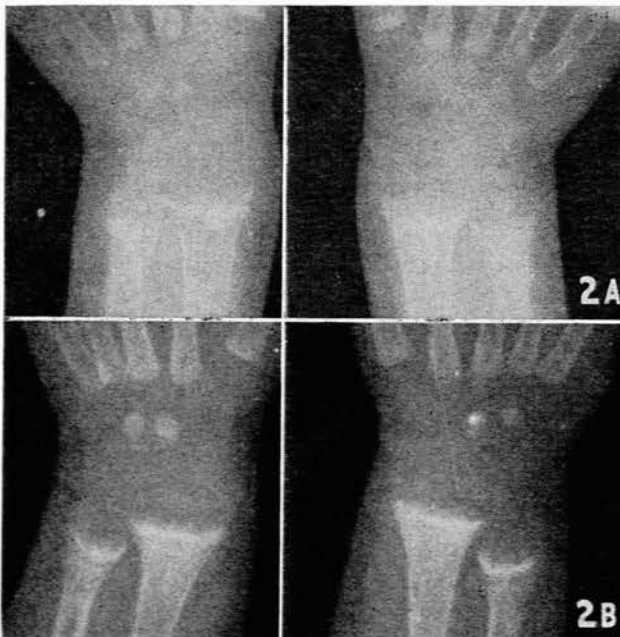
X-rays of patient V.L., aged 8 months.
